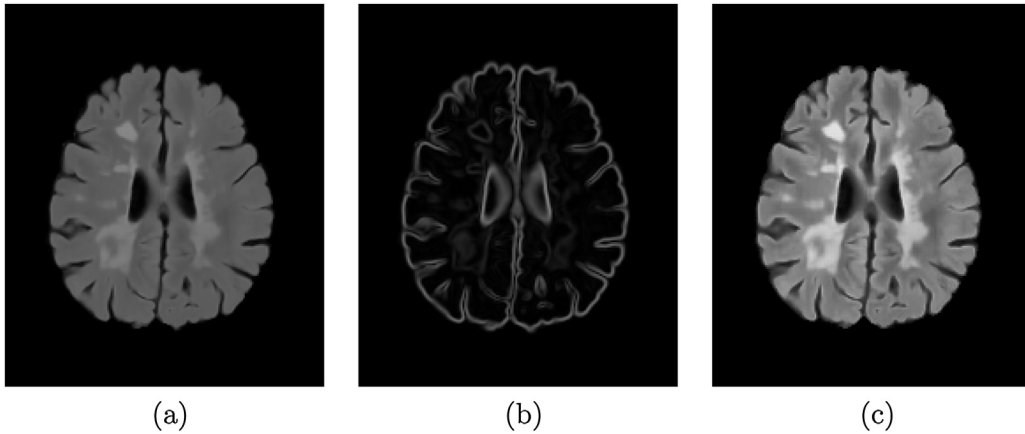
Intermediate image generation. (a) FLAIR image, (b) Sobel image, and (c) intermediate image.
